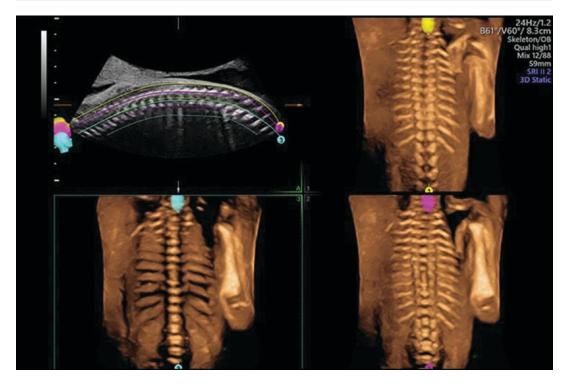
Volumetric ultrasound images of Spine in 3 (Three) views
